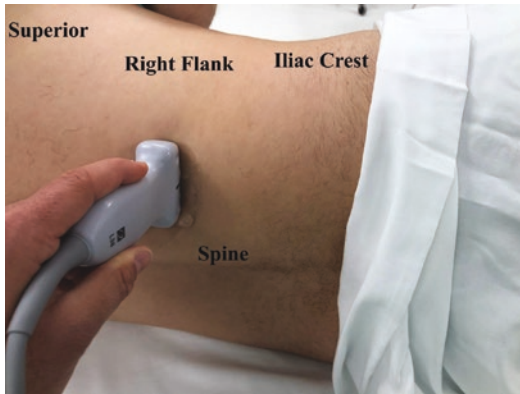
The patient is placed in the left lateral decubitus position. The linear ultrasound probe being placed at the superior-medial portion of the superior lumbar triangle, just inferior to the 12th rib and just lateral to the spine to evaluate for a lumbar hernia. This is where the probe starts when employing the LAFS method
